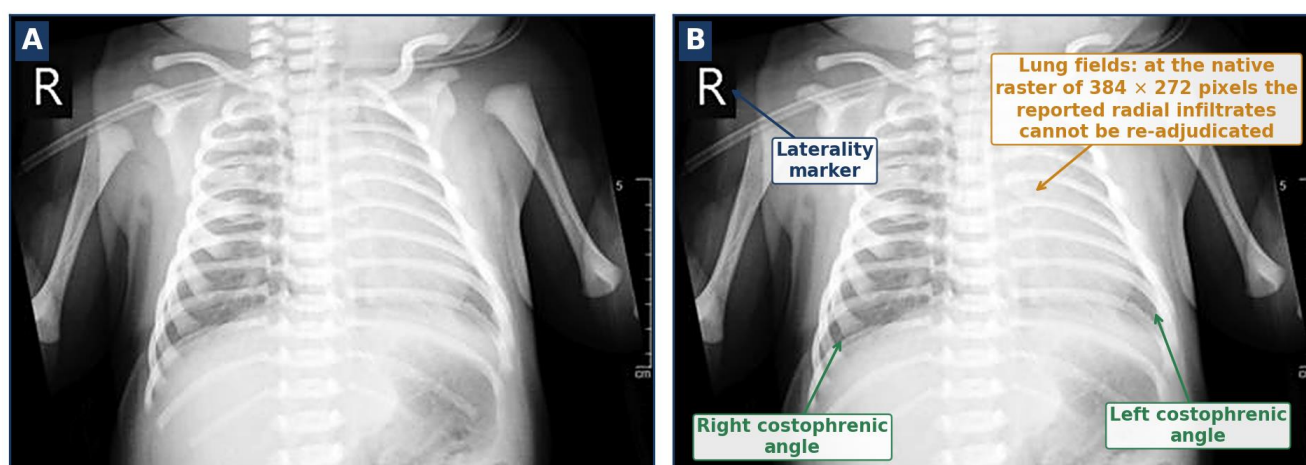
The chest radiograph obtained on the first day of life. (A) The image as it appears in the source record, with contrast windowed to the 0.5th and 99.5th percentiles and no other processing. (B) The same image with the landmarks that can be identified at this reproduction resolution. The radiological report describes mild thickening of the horizontal fissure with bilateral diffuse radial infiltrates extending to the peripheral lung fields, no reticulogranular opacity, good expansion, a cardiothoracic ratio below 60% and sharp costophrenic angles, and gives the impression of transient tachypnoea of the newborn. The image is available only at a native raster of 384×272 pixels, which over the 2.62 in at which each panel is printed is about 147 pixels per inch; the parenchymal findings on which that impression rests therefore cannot be independently re-adjudicated here, and no annotation in panel B asserts them. The identity of the infant is not deducible from the image, and no burned-in text was present in the source. The tubing crossing the upper right hemithorax is the support circuit lying on the chest wall; it is not commented on in the report.
